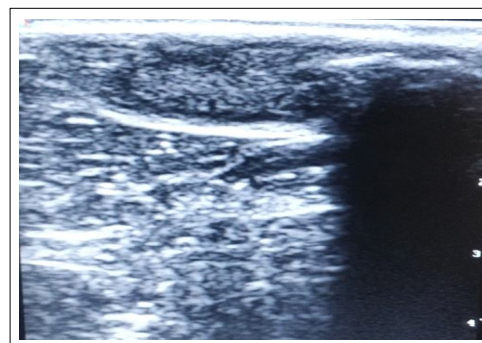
Group I pre-operative ultrasound of urethra- cross section.
